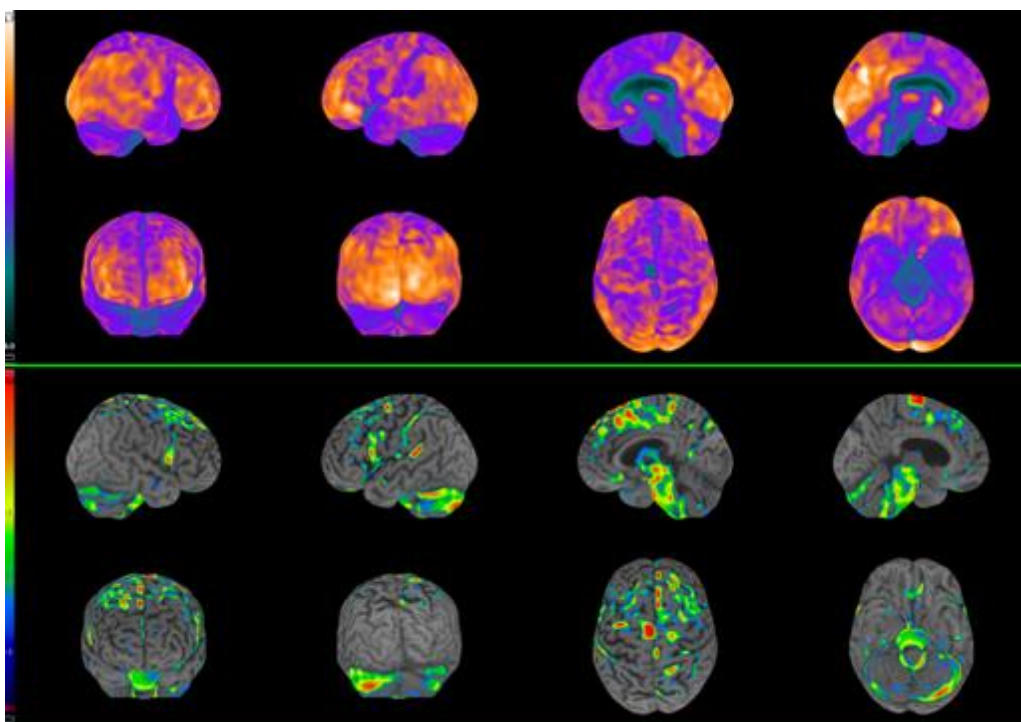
FDG-PET disclosing PSP hypometabolic pattern
